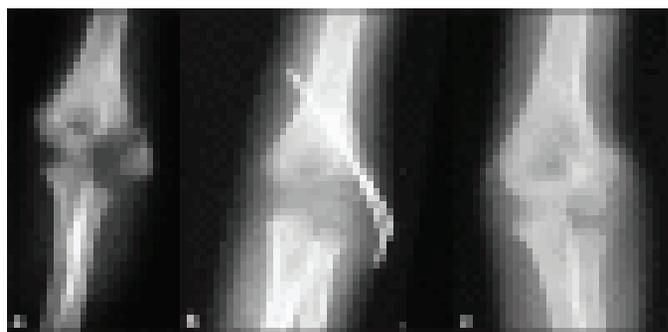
X-ray of the elbow joint (anteroposterior view) showing
